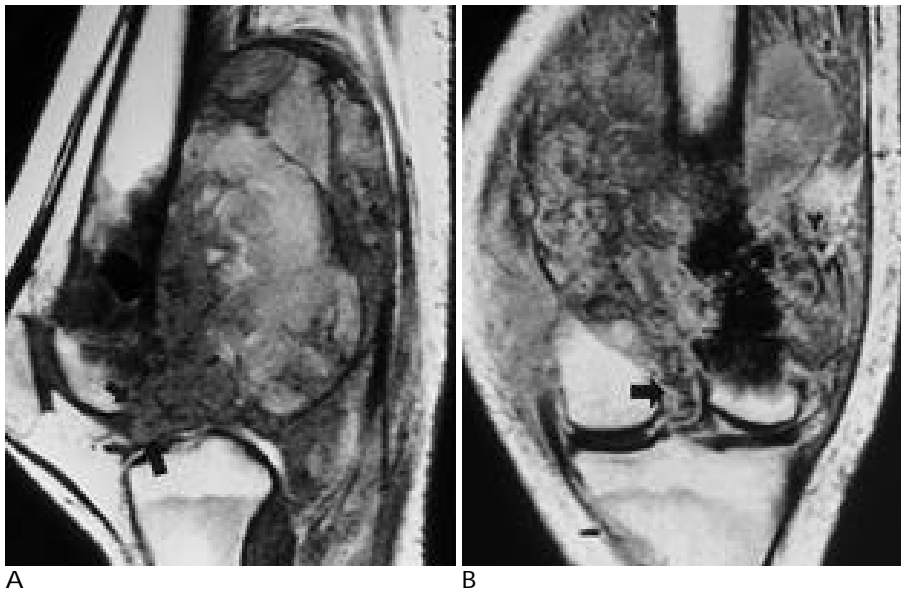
A 19-year-old man with osteosarcoma in the distal femur. A. T1-weighted sagittal image shows large soft tissue mass arising from distal femur. Cortical destruction (small arrow) and intrasynovial component of the mass (arrow) are noted. B. Enhanced coronal image shows mass in the intercondylar fossa (arrow)
